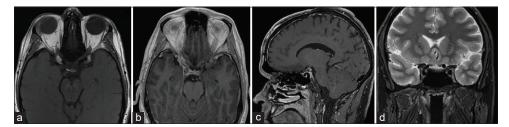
(a): Magnetic resonance imaging (MRI) noncontrast T1-weighted image (axial view) demonstrating heterogeneous intermediate to low intensity, (b): MRI postcontrast T1-weighted image (axial view) demonstrating minimal enhancement, (c): MRI postcontrast T1-weighted image (sagittal view) demonstrating minimal contrast enhancement, (d): MRI T2-weighted image (coronal view) showing low signal intensity and its relationship with the oculomotor nerve.
